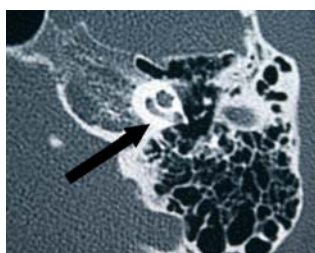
Patient 2; axial CT scan of the left basal cochlea turn with ossification zone (arrow).
